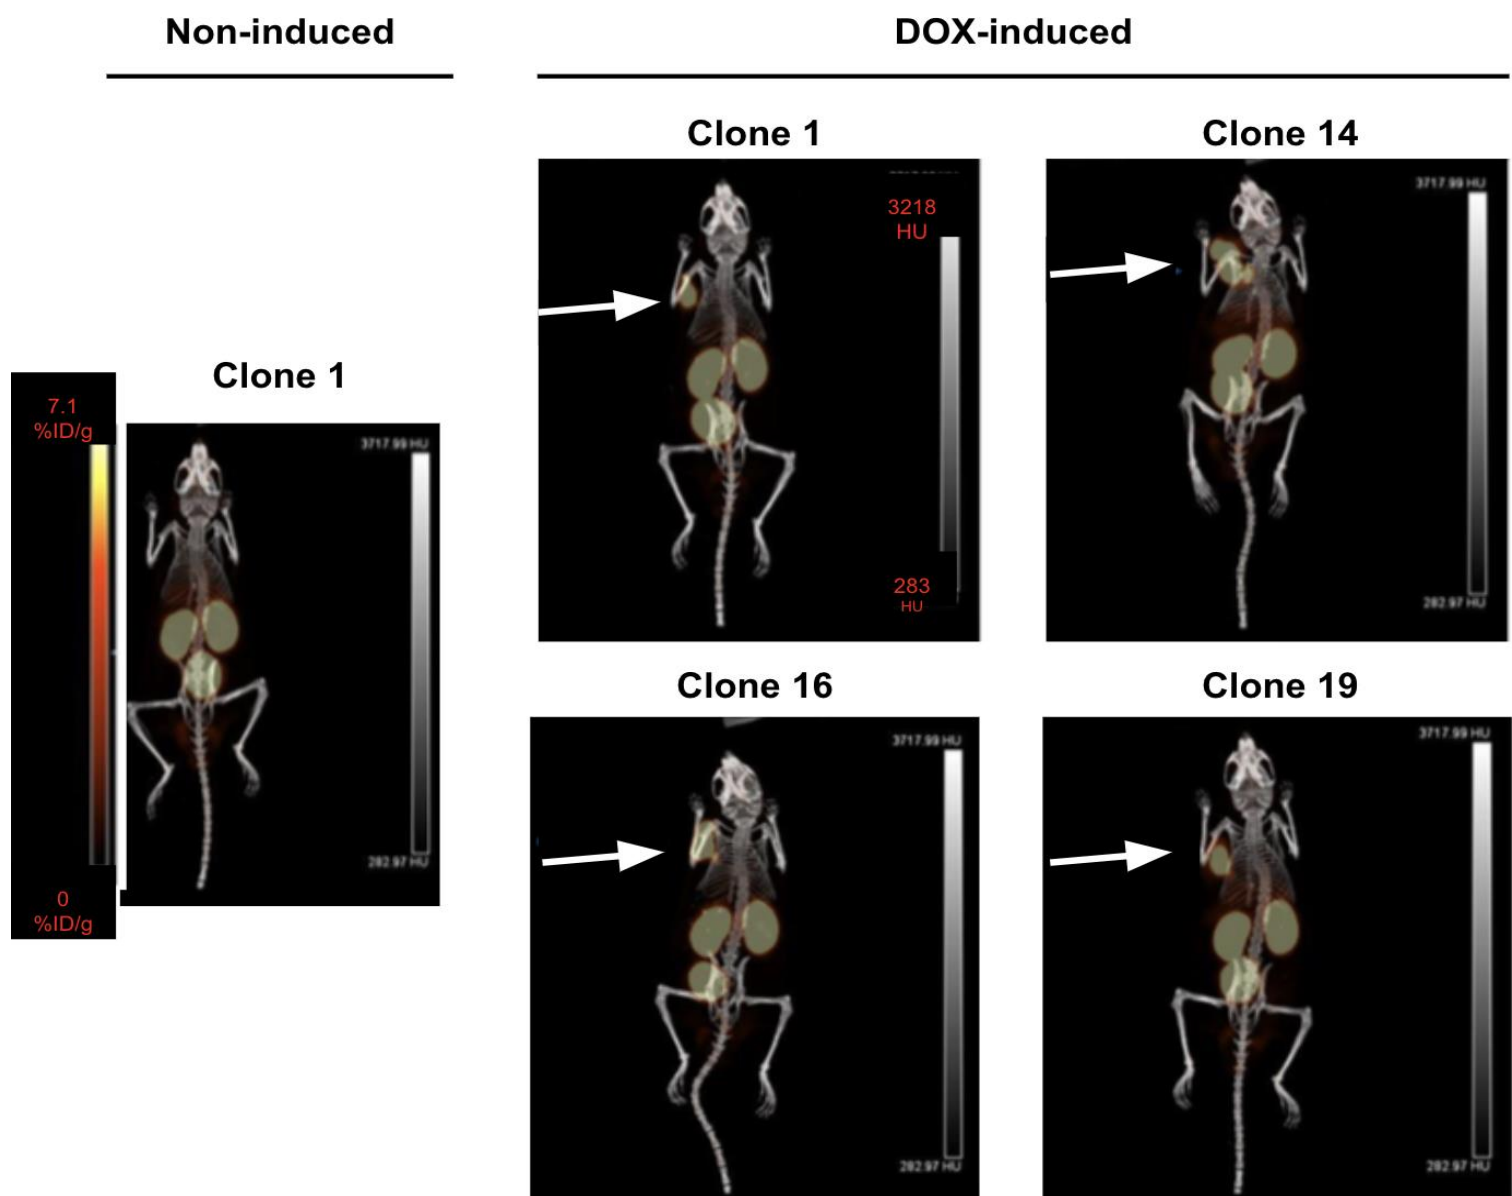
$^{18}\text{F}$ -DCFpyL binding response to hPSMA TRAMP-C2 in-vitro and in-vivo.
